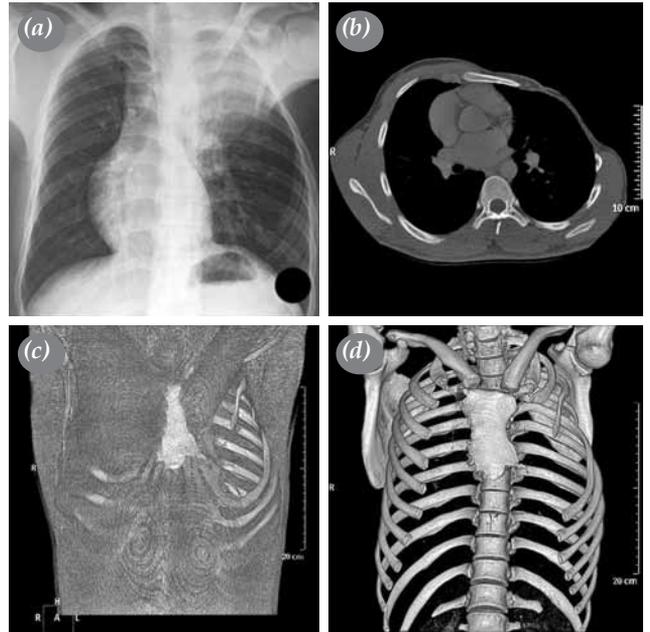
(a) Posteroanterior chest radiograph demonstrating dextrocardia with partial rib agenesis. (b) Axial computed tomography images showing a sunken chest, the absence of left pectoral muscles, and partial rib agenesis, (c, d) volume rendering images of computed tomography scan showing partial absence of left pectoral muscles, and partial rib agenesis (Case 7).
